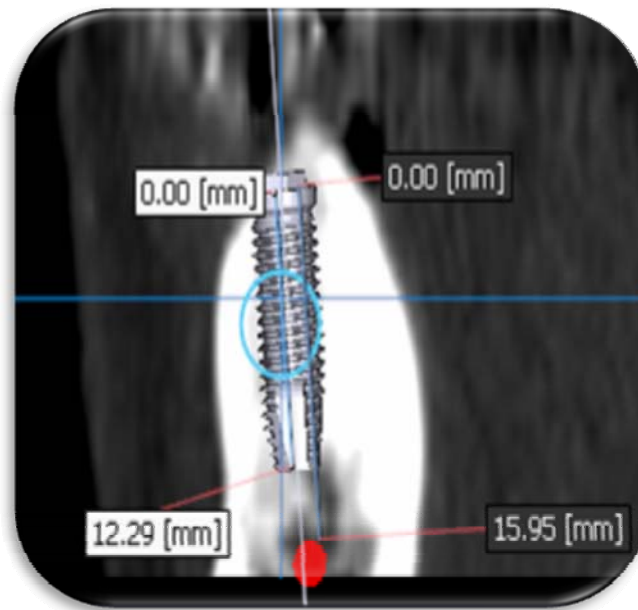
Measurement of D1. D1 was the difference between the distance from the implant platform to the anatomic structure (e.g., inferior wall of the maxillary sinus or superior border of the mandibular canal) in presurgical CBCT and the distance from the implant platform to the implant apex.
